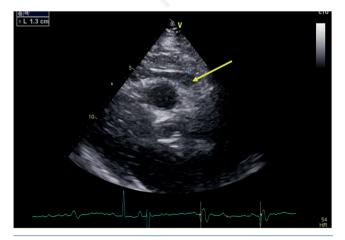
Parasternal long axis view. Epicardial adipose tissue (arrow).
